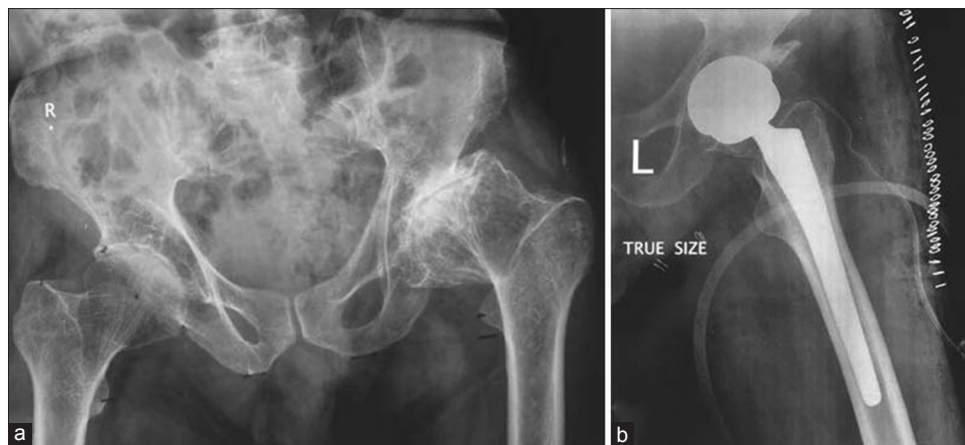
(a) Preoperative radiograph of pelvis with both hips showing a large osteophyte at the floor of the acetabulum in the left hip (b) Postoperative anteroposterior radiograph showing left hip arthroplasty
